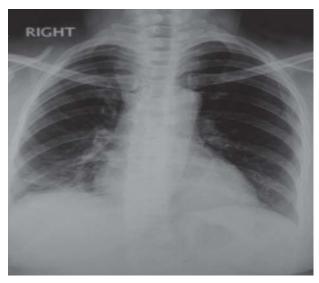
Follow-up chest radiograph (postero-anterior view) showing no evidence of recurrence.
